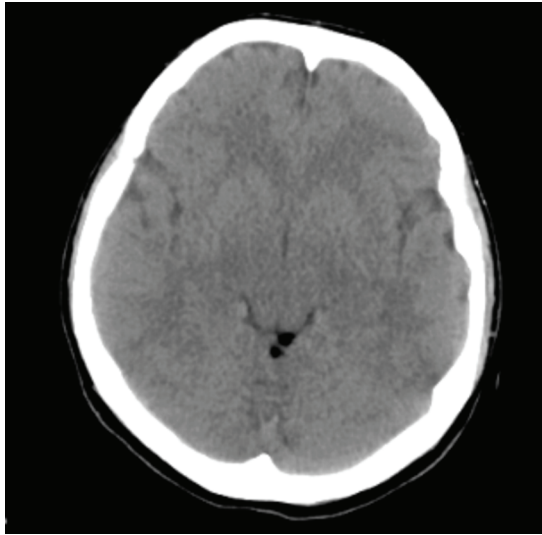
Intracranial lipomas: Axial cranial CT image shows low density quadrigeminal cistern lipoma
